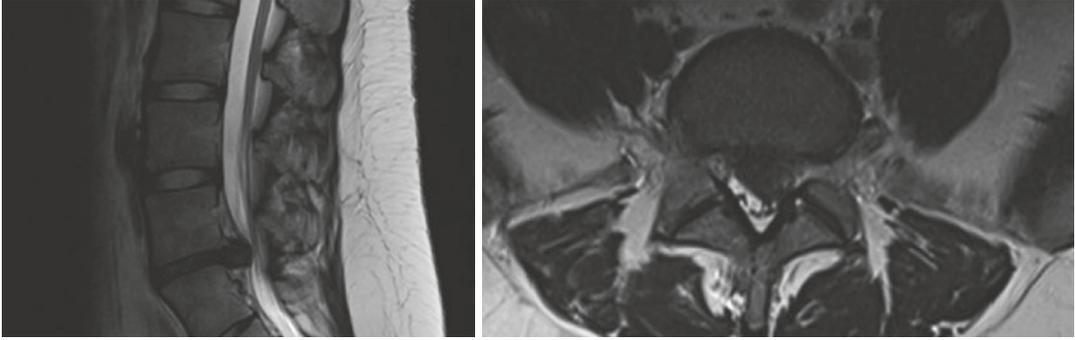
L5-S1 left lumbar disc herniation on MRI
